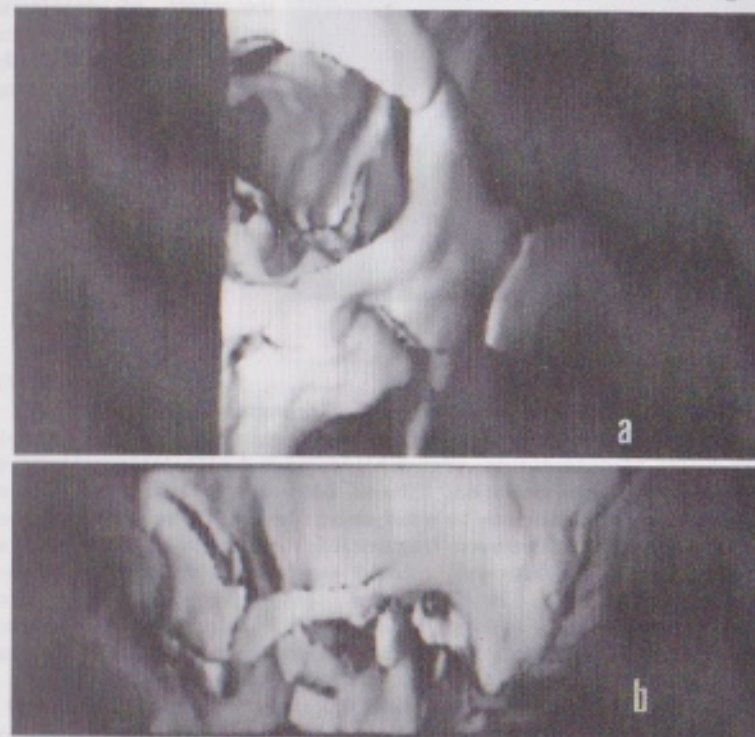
Three dimensional computed tomography of case 1. Fig 1-a taken from the front shows medioposterior displacement of fractured fragment of the left malar eminence. Fig 1-b taken from left lateral aspect shows medial displacement of fractured fragment of the zygomatic arch and coronoid fracture medial to the zygomatic arch.
